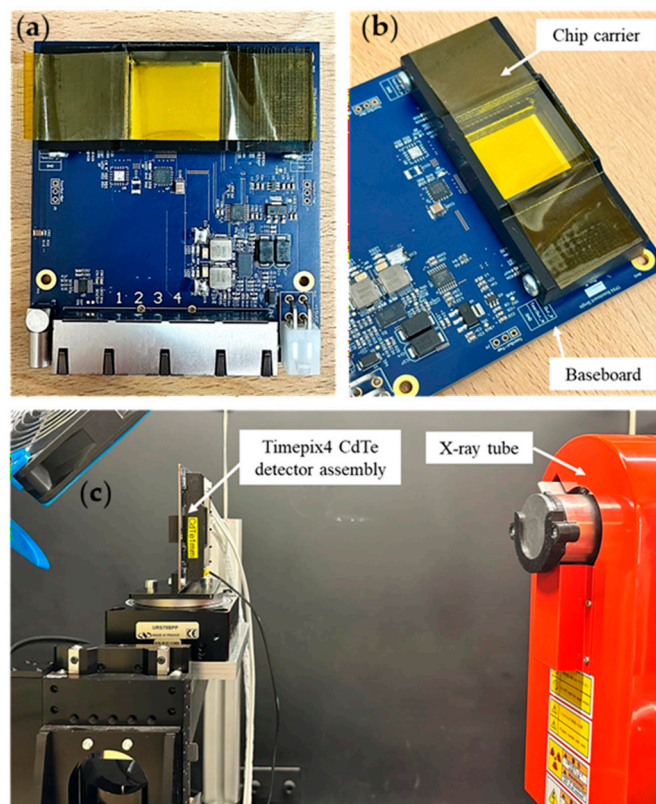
(a) CdTe Timepix4 hybrid pixel detector, mounted on a baseboard. (b) Close-up of the assembly showing the Timepix4 carrier chipboard mounted on the baseboard. (c) Experimental setup for X-ray image acquisition.
